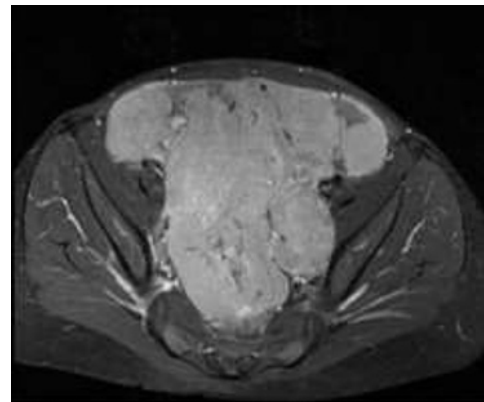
Contrast enhanced MRI demonstrates extensive enhancing peritoneal mass.
